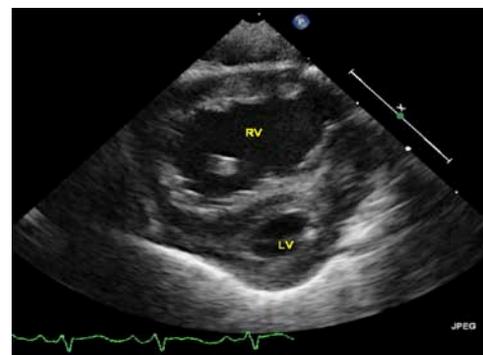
Two dimensional echocardiographic precordial short axis view of the heart in a patient with Hypoplastic Left Heart Syndrome demonstrating the hypoplastic left ventricle (LV) and a large right ventricle (RV).
